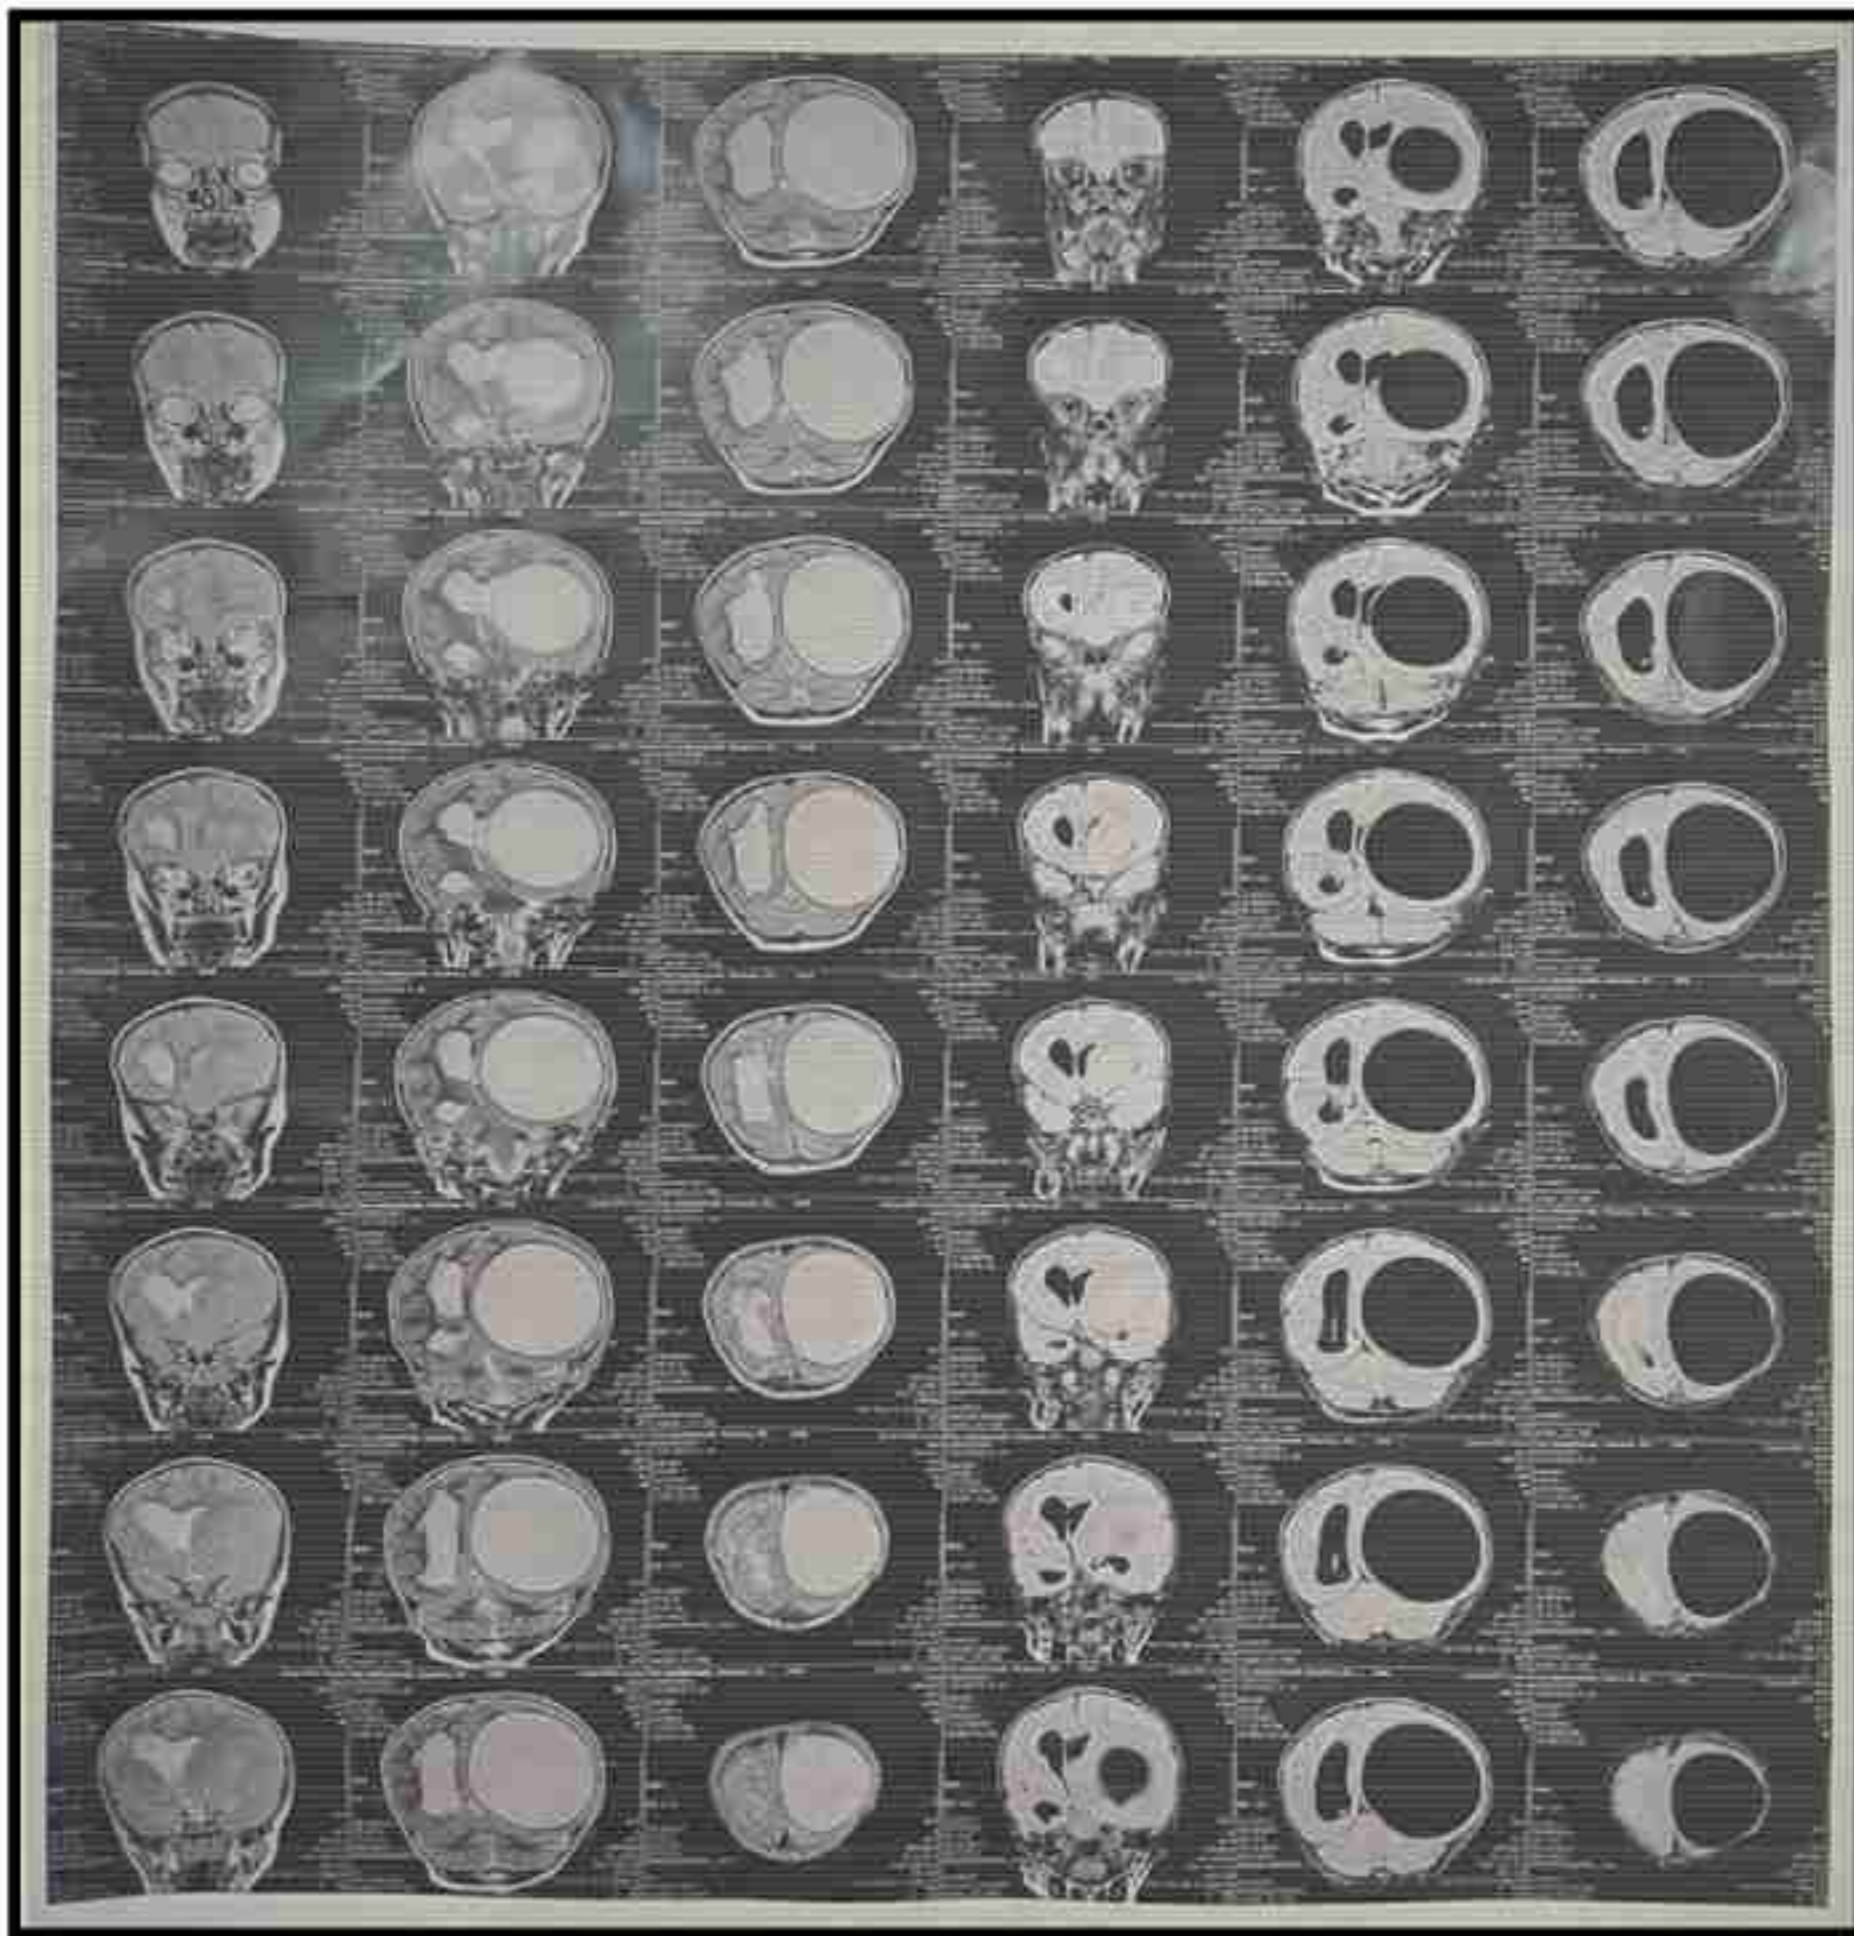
Coronal T1-weighted and T2-weighted images of the brain showing a well-defined T1 hypointense and T2 hyperintense lesion with no sign of perilesional edema in the left temporo-parieto-occipital lobe with significant mass effect and midline shift.
